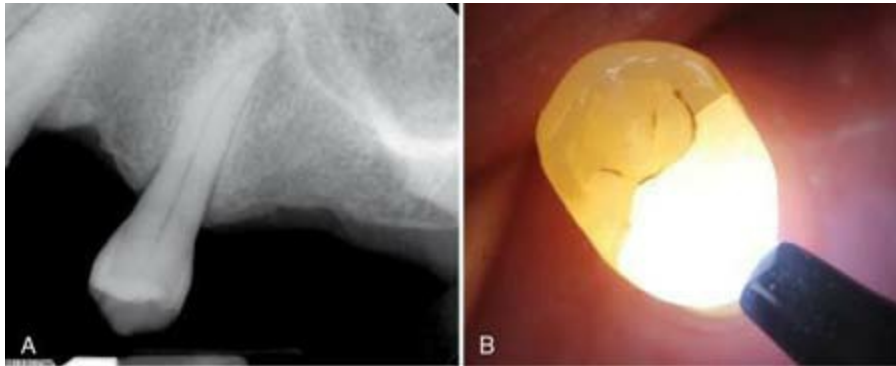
A, Preoperative radiograph. B, Transillumination.
